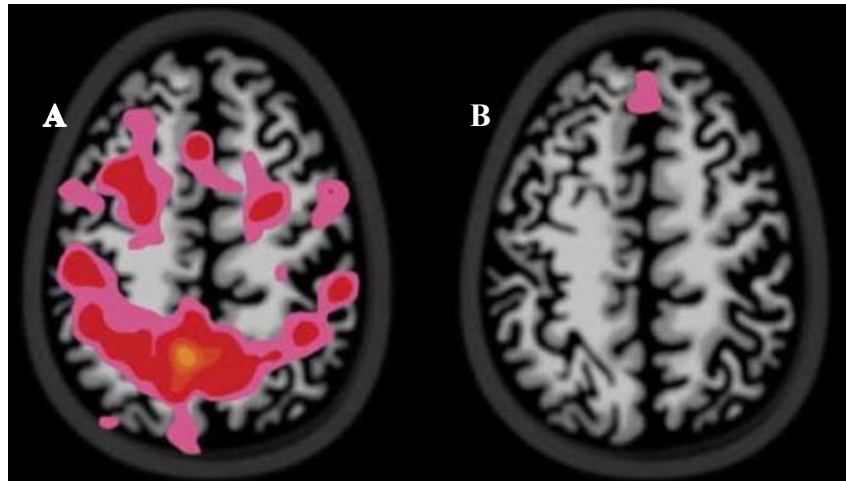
A – B (MRI comparison): In Figure A, an MRI of a 15-year-old who has never consumed alcohol is shown. In Figure B, an MRI of a 15-year-old with heavy alcohol consumption is presented for comparison. Colored regions indicate active areas. During this test, activity in memory-related regions was marked and compared.
